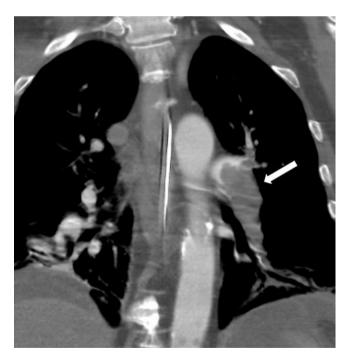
Coronal projection from CT angiogram of the pulmonary artery shows large filing defect (*arrow*) in the left main and lower lobe pulmonary arteries
